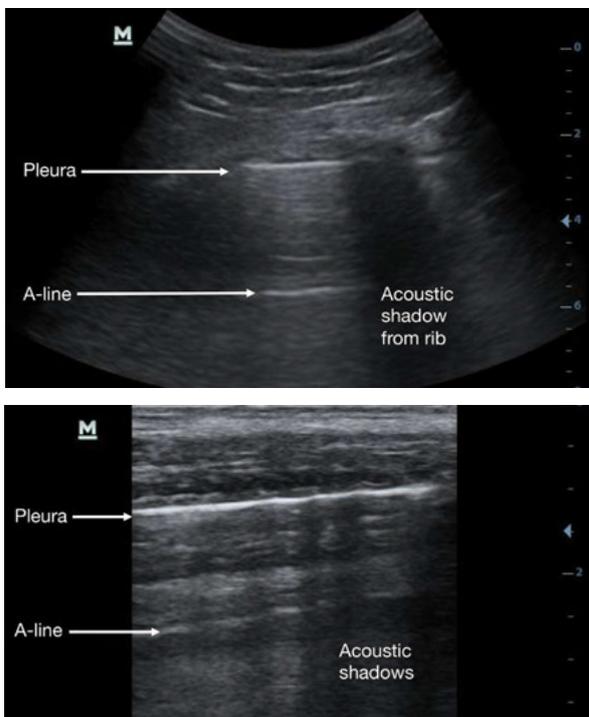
Convex (top) and linear (bottom) ultrasound scans demonstrating horizontal, parallel A-lines.
